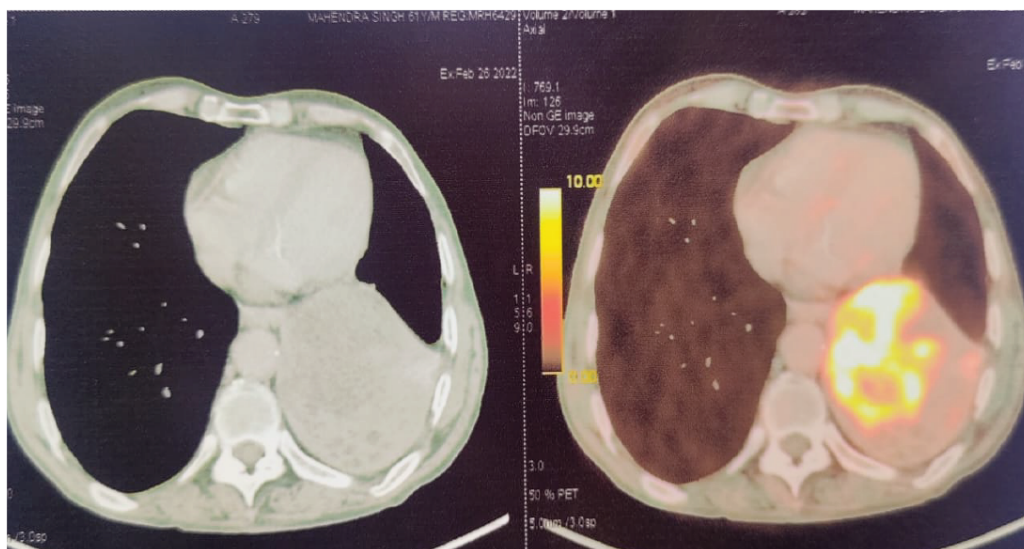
Lesion was seen encasing the left inferior pulmonary artery, mediastinal pleura and descending thoracic aorta. FDG uptake was seen in multiple upper, lower paratracheal, AP window and subcarinal lymph nodes and uptake could not be seen elsewhere in the body therefore a final diagnosis of PPL was made.
